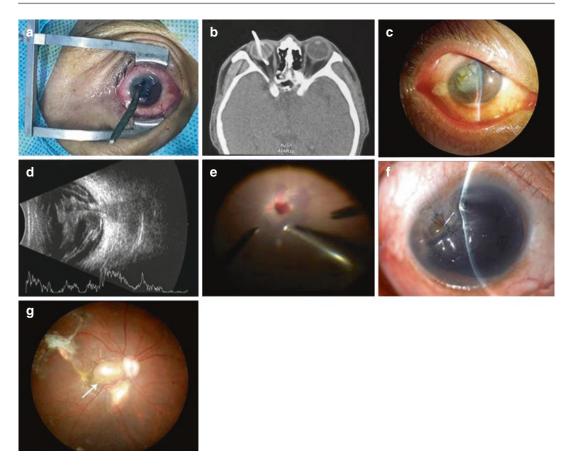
(a, b) A 44-year-old man was injured by an iron nail on the right eye with the vision of hand movement, and the long iron nail penetrated the eye from cornea to orbit confirmed by CT. (c) The slight exudates in the anterior chamber was observed 2 days after emergency surgery for suturing corneal wound. (d) A large amount of vitreous hemorrhage was observed by ocular
